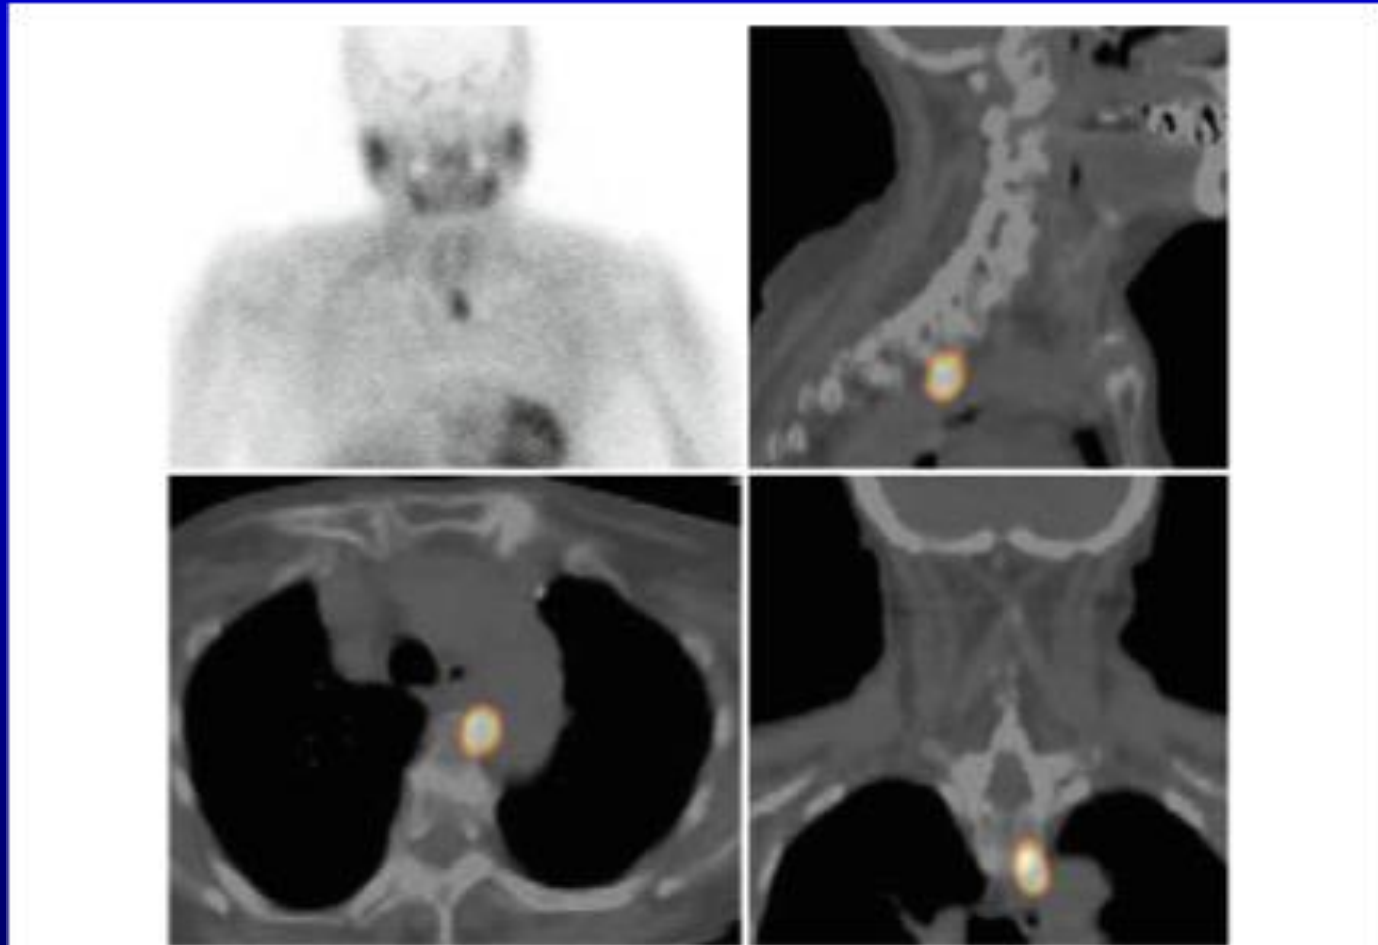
^{99m}Tc -sestamibi scintigraphy images of a left superior parathyroid adenoma which has migrated towards the posterosuperior mediastinum by gravity. Planar image
